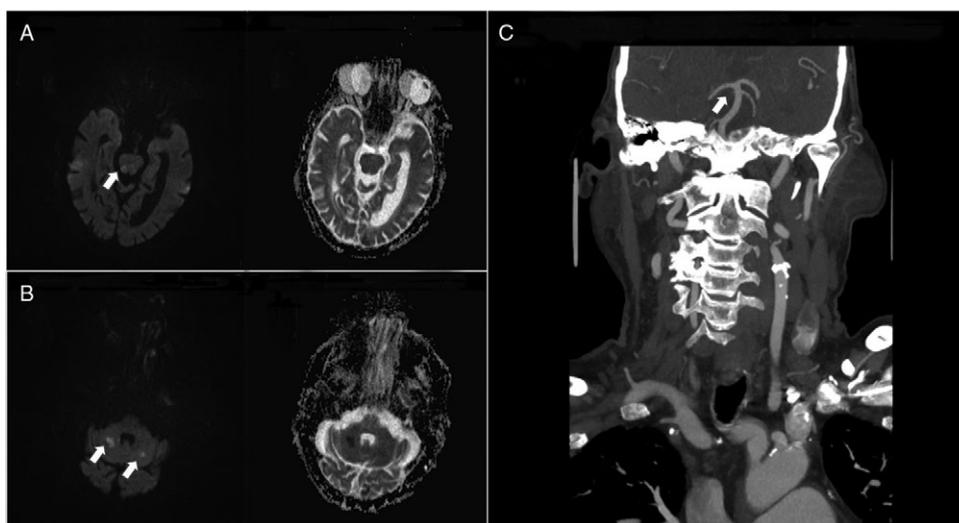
A: MRI (diffusion-weighted imaging [DWI], left; apparent diffusion coefficient [ADC], right) showing acute infarct in the right dorsolateral brainstem at the pontomesencephalic junction. B: MRI (DWI, left; ADC, right) demonstrating acute infarcts in the medial cerebellar hemispheres. C: CT angiography showing a clot in the superior cerebellar artery (arrow).
